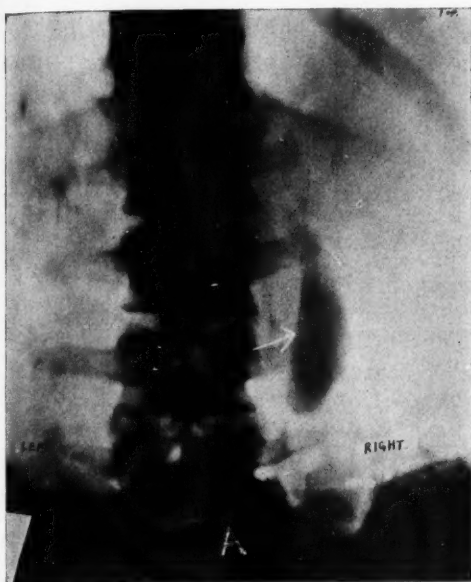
Case with jaundice and pain in gall-bladder region diagnosed as gallstones clinically, but negative for stone roentgenologically. Operation revealed no gall-bladder pathology and no stones. Symptoms caused by hepatitis of undetermined nature.
